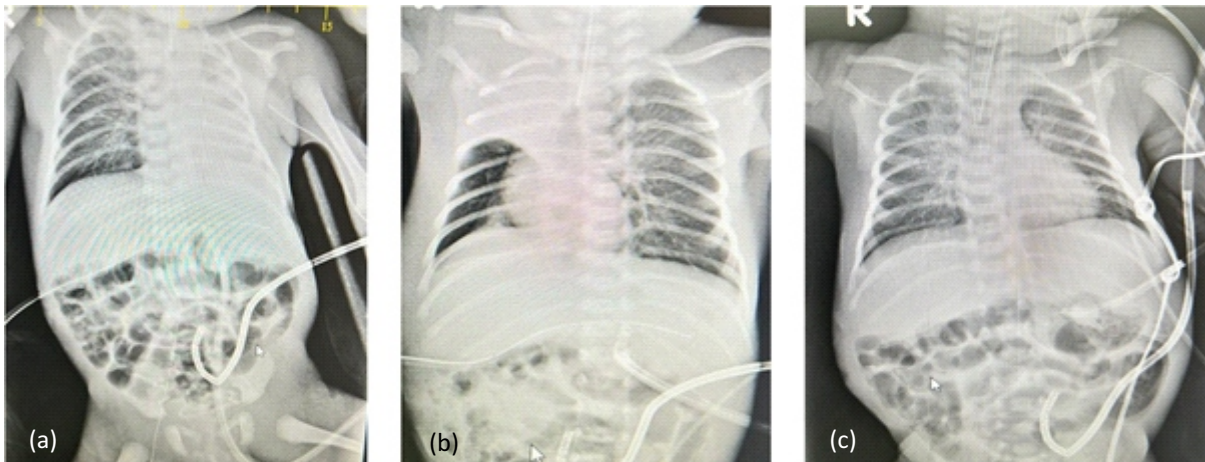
Serial xrays of baby showing left lung collapse (a), Right upper zone collapse (b), no collapse in both lungs (c)
